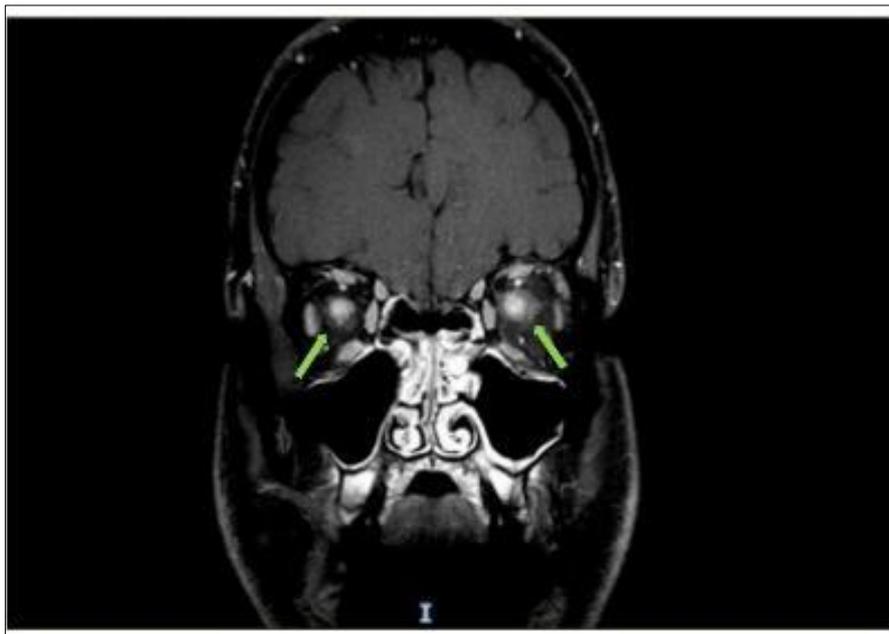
Brain and orbit MRI frontal section T1 sequence after gadolinium injection: enhancement after injection of both optic nerves
